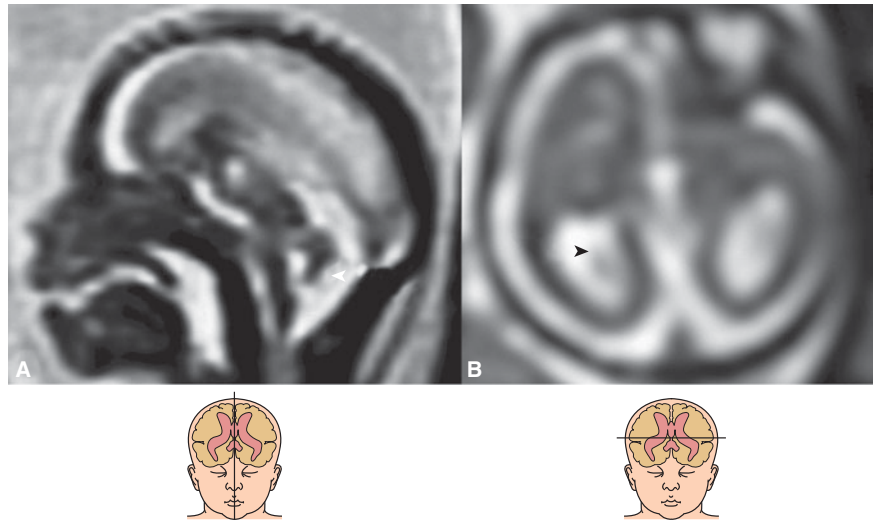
Single shot fast spin echo (SSFSE) fetal magnetic resonance imaging (MRI) during the third trimester of a patient with pyruvate dehydrogenase deficiency. (A) Sagittal section shows callosal and pontocerebellar abnormalities (*arrowhead*). (B) Axial section shows ventriculomegaly, particularly of the posterior horns (*arrowhead*).
